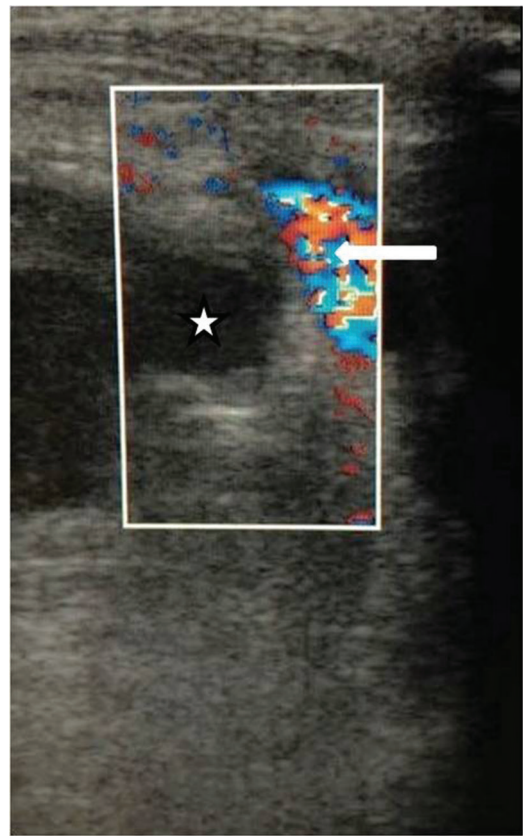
Color Doppler image after percutaneous thrombin injection showing no residual color flow in the pseudoaneurysm (asterisk), with normal flow in the inferior thyroid artery (white arrow).
